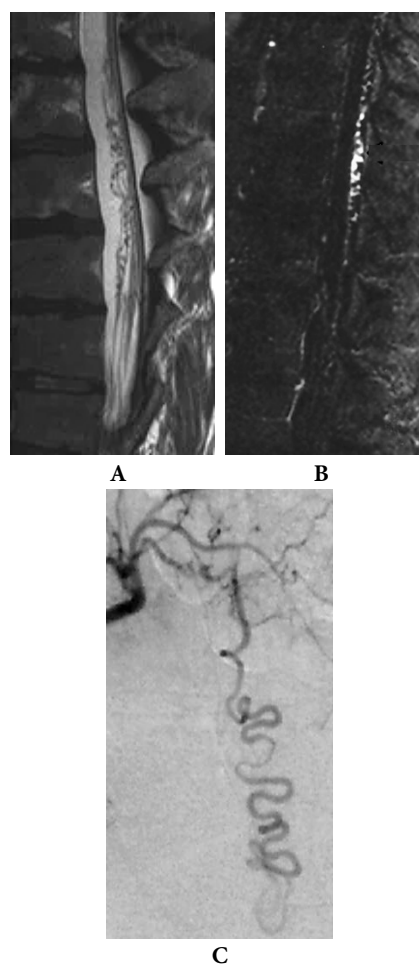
SDAVF aspects on A - MRI - T2; B - MRA and C – Catheter angiography
